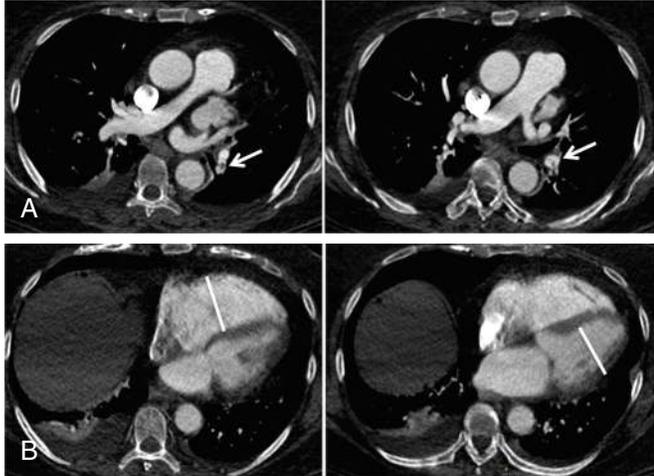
A, Segmental pulmonary embolus (arrows) on computed tomography pulmonary angiogram (CTPA). B, Right ventricle to left ventricle ratio >1.0, suggestive of heart strain.
